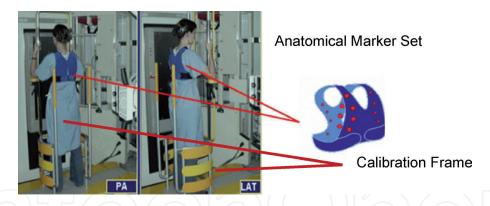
Biplanar X-ray (posterior anterior (PA) and lateral view) acquisition system with calibration apparatus (Cheriet et al. [7]).
